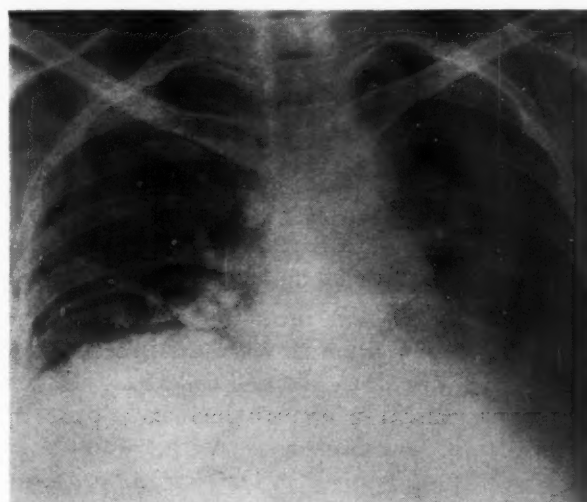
Chest x-ray (Case 1), February 23, 1954; diffuse interstitial striations throughout both lung fields; irregular density, left lower chest.
